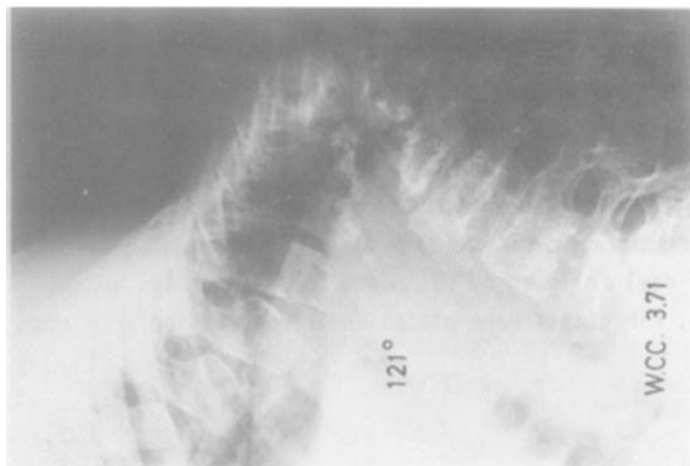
a. Lateral radiograph before correction.
